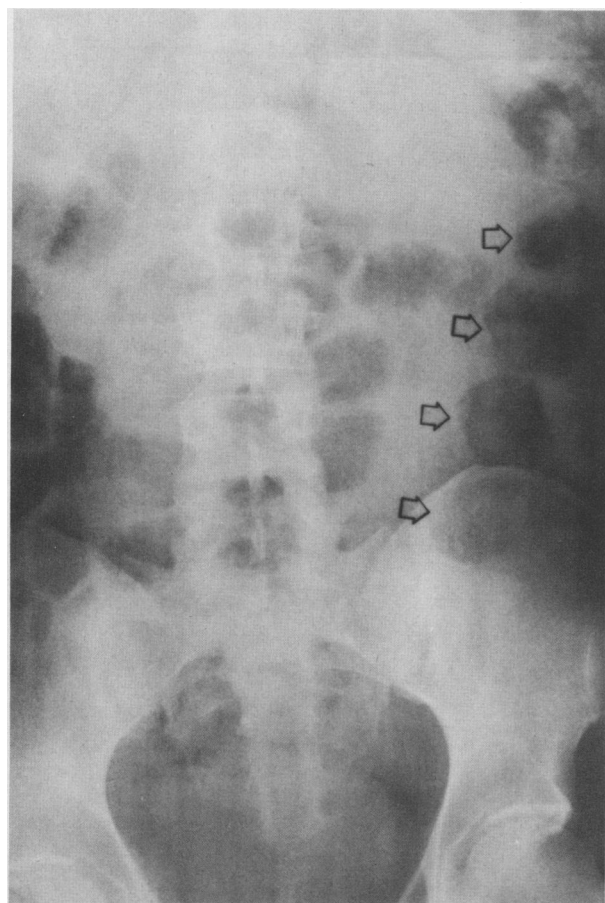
The third patient's abdominal radiograph reveals rounded radiolucent masses in column within the descending colon (arrows)
